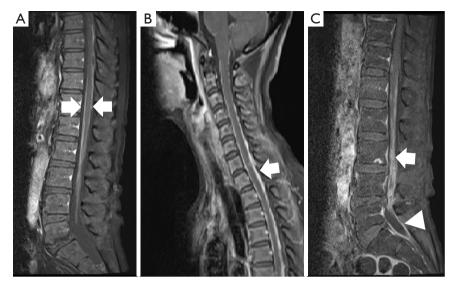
Spinal postcontrast MRI. (A) Linear enhancement is known as the railway sign on the surface of the spinal cord (arrows). (B) Abnormal enhancement on the surface of cervicothoracic spinal cord and the thickened dura mater (arrow). (C) Lower spinal MRI. The MRI demonstrates abnormal enhancement of the spinal cord (arrow) and linear enhancement of the dura mater (arrowhead). MRI, magnetic resonance imaging.
